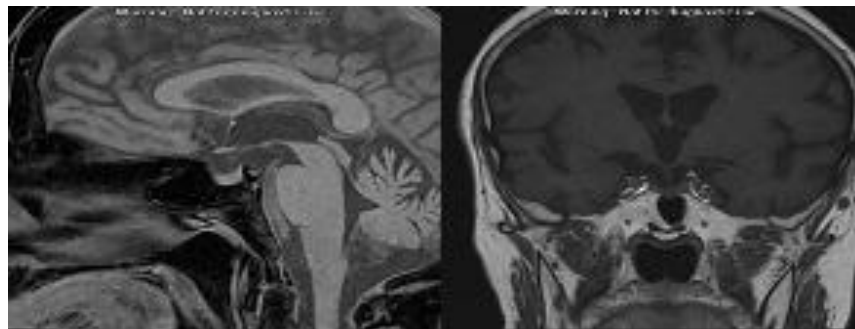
Sagittal and coronal view of the pituitary MRI: normal sellar region and absence of bright spot.
